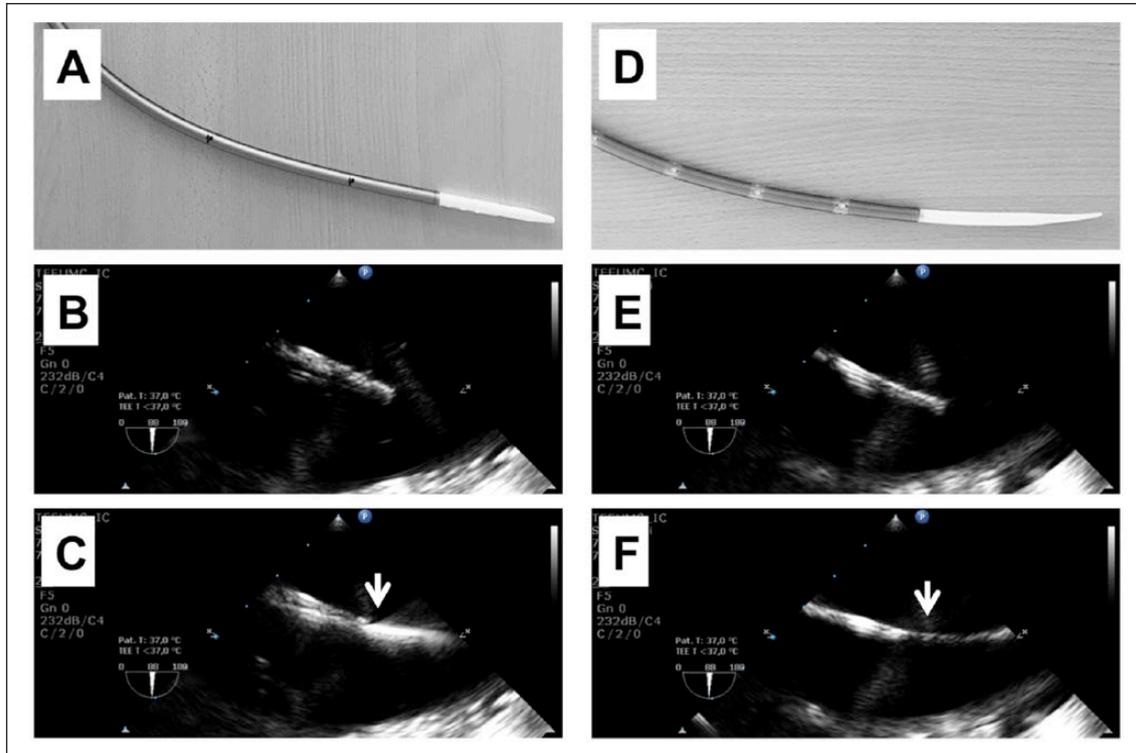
Echographic image of a single-stage and a multistage drainage cannula obturator tip. A. Single-stage venous drainage cannula (Medtronic Bio-Medicus 25F®) with obturator. B. Echographic image of the obturator tip in the venous drainage cannula *without* a guidewire using a TEE probe in a water bath (same single-stage venous drainage cannula as in A.). C. Identical echographic view of the obturator tip as in B, but *with* a guidewire inserted through the obturator. Please note that the tip of the obturator cannot precisely be discriminated due to ultrasound scatter in the transition zone between obturator tip and guidewire. D. Multistage venous drainage cannula (Maquet HLS 25F®) with obturator. E. Echographic image of the obturator tip in the venous drainage cannula *without* a guidewire using a TEE probe in a water bath (same multistage venous drainage cannula as in D.). F. Identical echographic view of the obturator tip as in E, but *with* a guidewire inserted through the obturator. Please note that the tip of the obturator cannot precisely be discriminated due to guidewire-related ultrasound scatter in the transition zone between obturator tip and guidewire.
